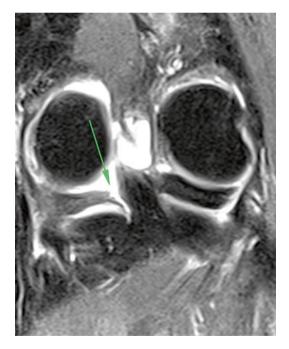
Coronal T2-weighted fat-saturated image shows a posterior root tear of the medial meniscus. Only a tiny remnant of the root is not retracted (*arrow*)
